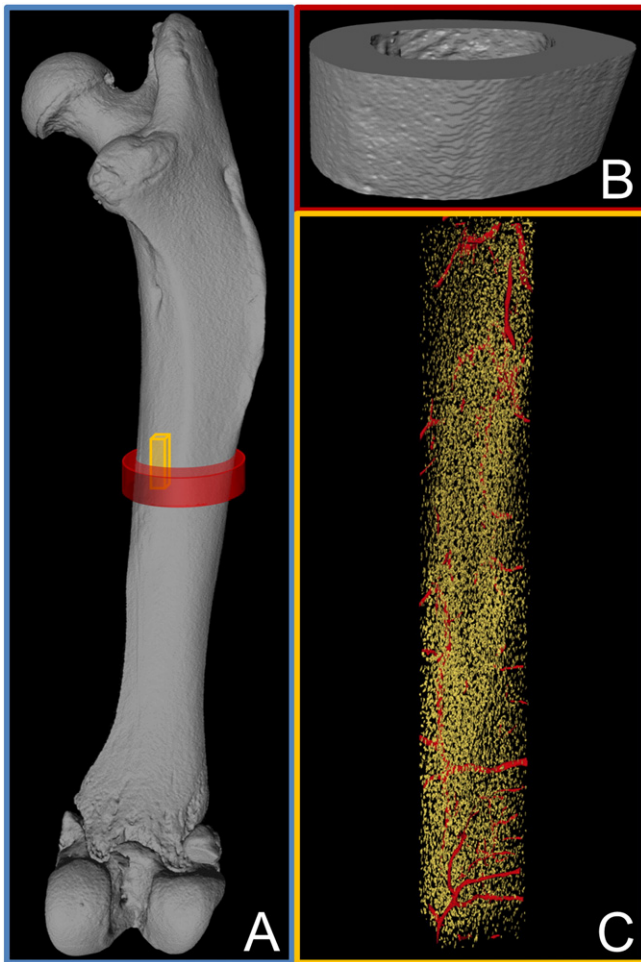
Length scales investigated in this study range from A the whole bone (blue box) to B the tissue level (red box) and C the material level (yellow box). All images are renderings of μ CT data, the whole bone and tissue level from desktop μ CT and the material level from synchrotron μ CT. In the latter, the internal void space is shown with blood vessel canals in red and osteocyte lacunae in yellow. In the blue box, red and yellow boxes indicate the measured volumes at the tissue and material level, respectively.
